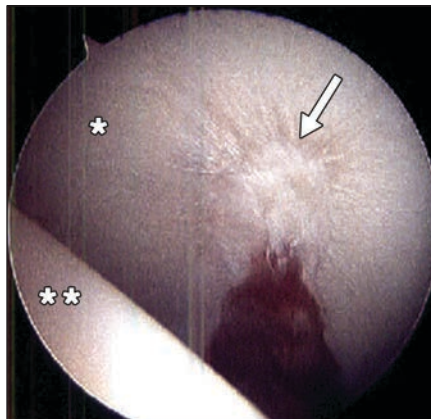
15-year-old girl with supraacetabular fossa. Supraacetabular fossa (arrow) is characteristically located at 12 o'clock position of acetabular roof, as shown in this coronal proton density-weighted image. Supraacetabular fossa can be distinguished from cartilage defect by location, presence of normal marrow signal intensity on MRI, and absence of cartilage defects on arthroscopy.
